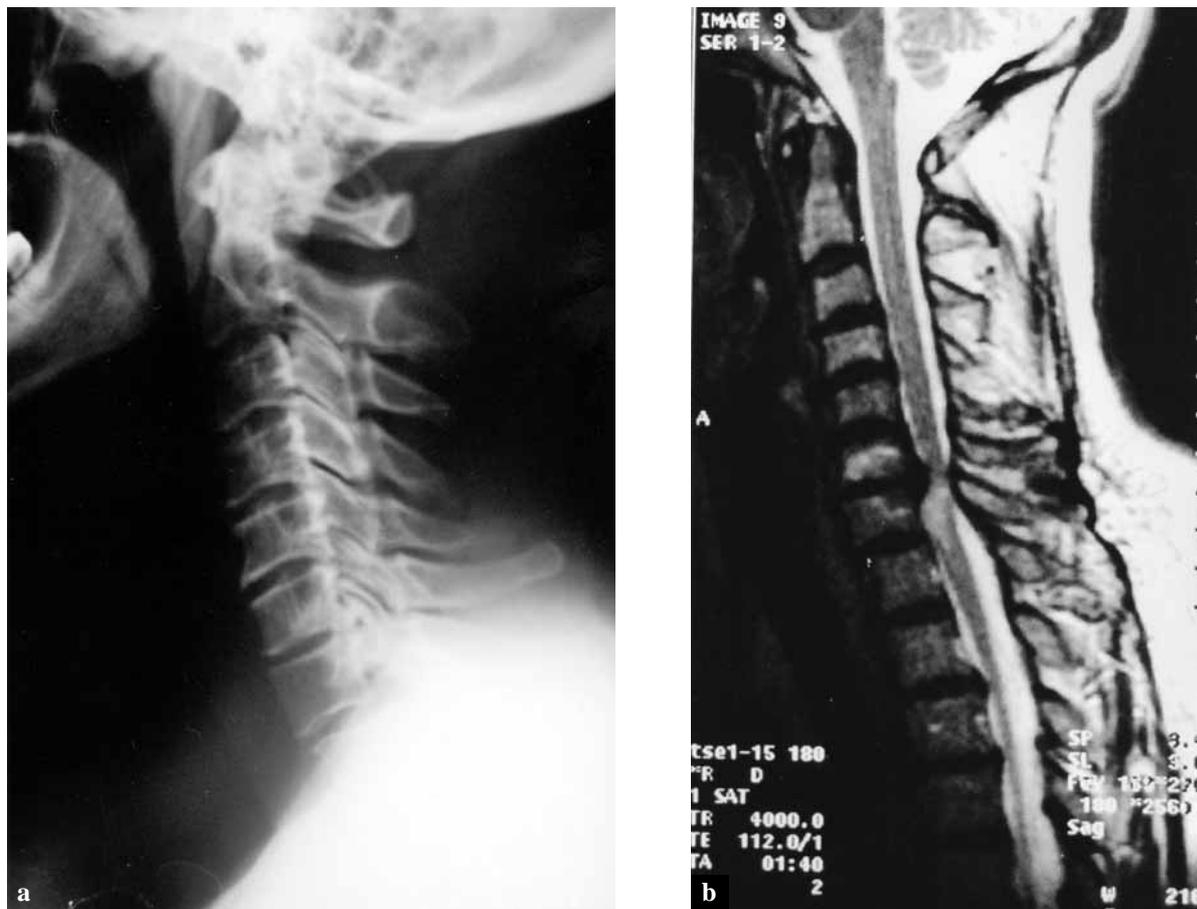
a. Lateral radiograph of the cervical spine of a patient with C6-C7 disc disease ; b. MRI of the same patient (sagittal section).
